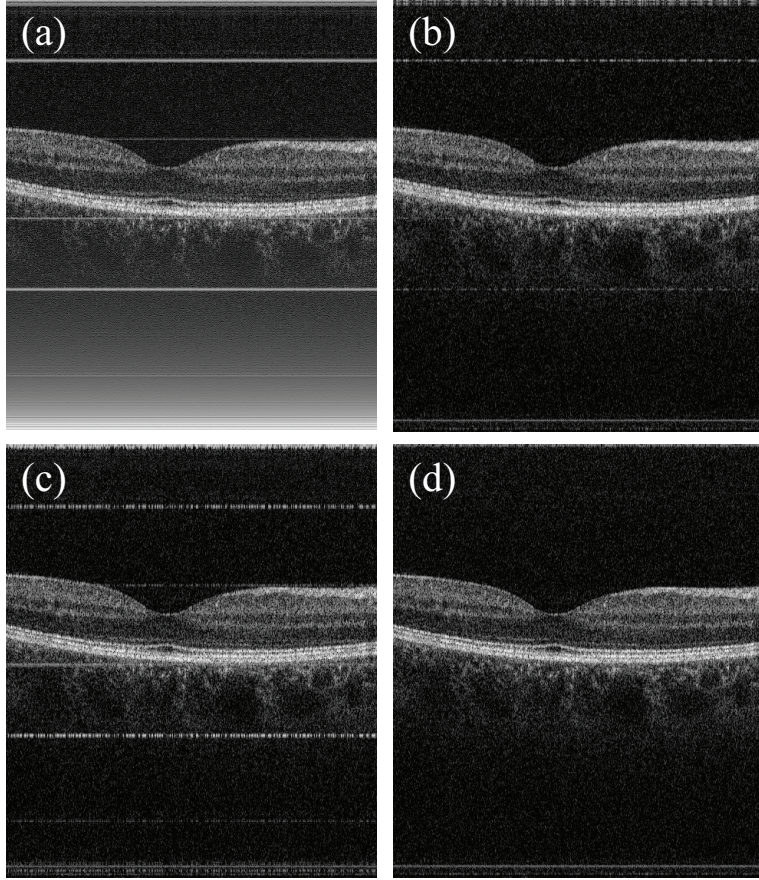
OCT images of the macular of a healthy volunteer. (a) A raw image without FPN removal, (b) FPN removal without spectral shift cancellation, (c) with spectral shift cancellation and FPN removal, but no zero-padding applied. (d) FPN removal was performed after spectral shift cancellation with  $1/16$  pixel resolution. (Source: Ju et al. *Advanced multi-contrast Jones matrix optical coherence tomography for Doppler and polarization sensitive imaging* [90])
